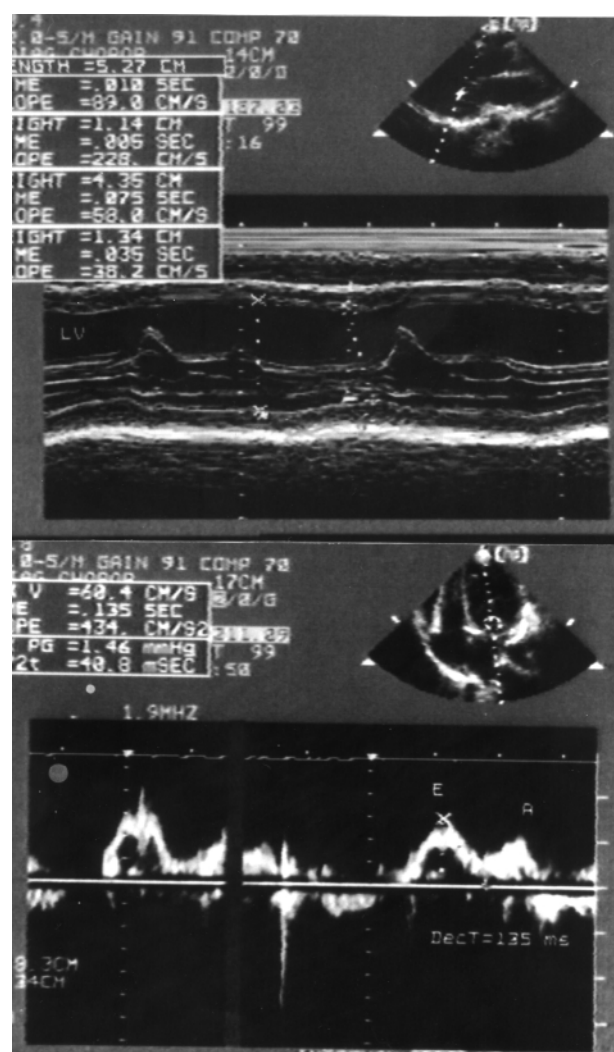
Case 1: Echocardiographic examination four days later. A, M-mode normal diastolic diameter of the left ventricle and improved ejection fraction (EF) – 47%. B, Mitral inflow pattern - longer deceleration time of E wave and E/A <2.
